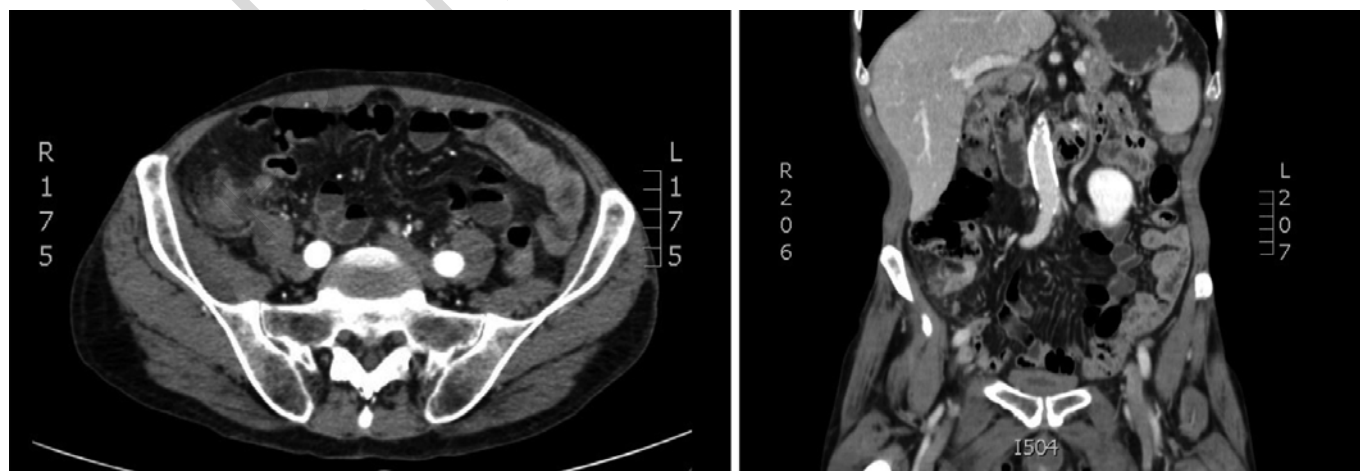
Abdominal CT showed the appendix dilated with marked mural thickening and mild fat stranding, surrounded by a dishomogeneous fluid collection compatible with acute appendicitis.
